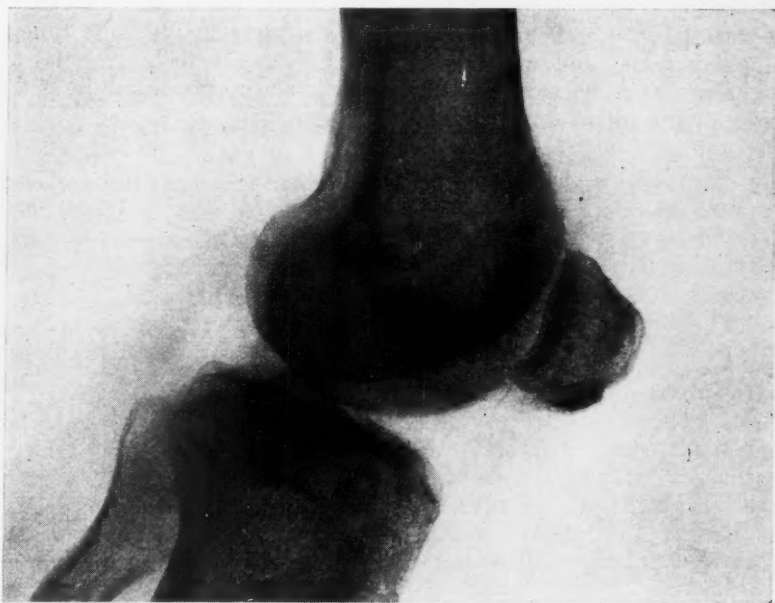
Roentgenogram made ten weeks after operation showing the repair. There was normal function in the knee joint.
